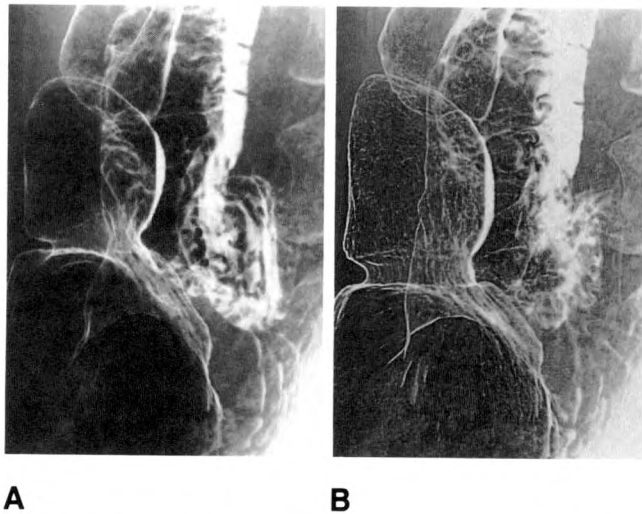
Comparison of film-screen (A) and computed radiographic (B) magnification images ($\times 3$) of air-barium double-contrast study of the stomach and duodenum. Exposure settings were 102 kVp, 6.4 mAs, 115 cm focus-film distance. Entrance skin exposure was 1.5 R (38.7 mC/kg). Exposure settings and entrance skin exposure were the same in both systems.
